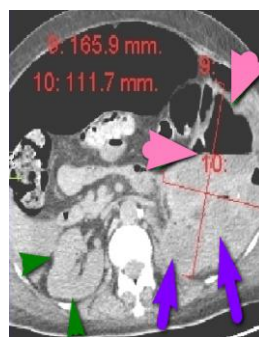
Axial CT images showed the left kidney filled with cystic lesions (purple arrows), INTRA-RENAL GAS (pink arrowheads), large hydro pneumoperitoneum (orange arrowheads), calcific renal stones (yellow arrows), fistulous communication between the anterior left kidney and the descending colon (red arrowheads). The right kidney (green arrows) was normal.
